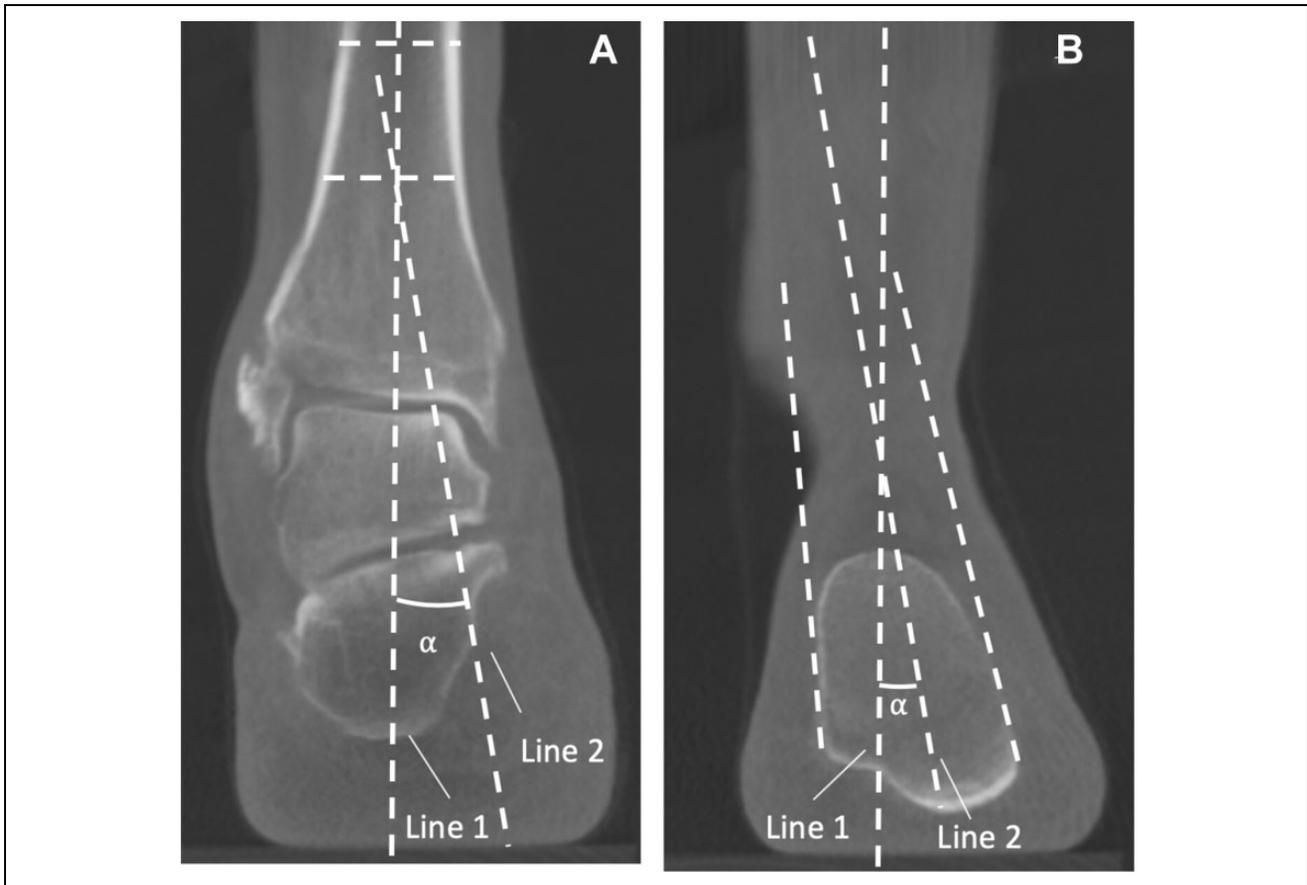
Example of manual CT hindfoot alignment angle (HAA). (A) The HAA (α) was calculated from the tibial axis (line 1) determined from coronal section (A), (B) and the calcaneal axis (line 2) determined from coronal section.
